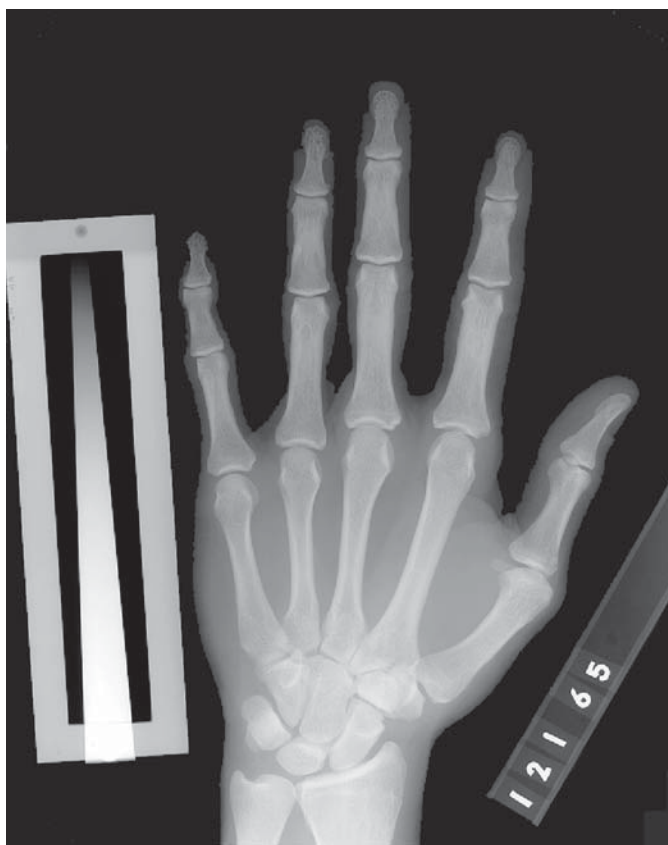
A radiographic photodensitometry hand film taken in 1965 of one of the Gemini astronauts. The Texas Woman's University aluminum wedge is seen next to the little finger.
